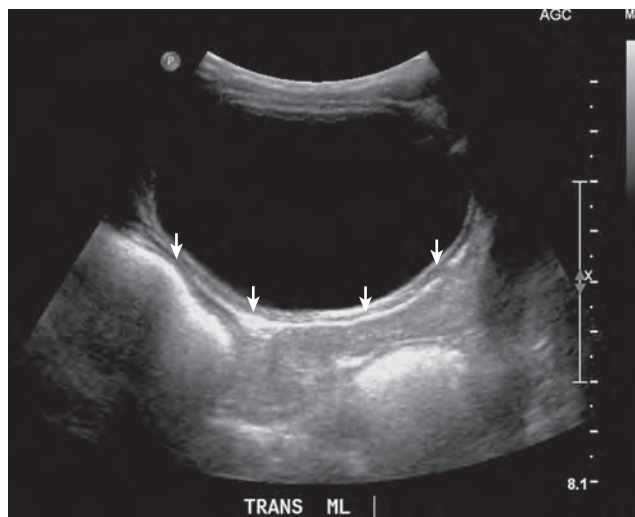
Assessment of fecal load in rectum during pelvic ultrasound. Stool is seen behind the bladder (arrows). Note bladder distention caused by incomplete emptying and infrequent voiding resulting from toilet avoidance secondary to pain with defecation.
